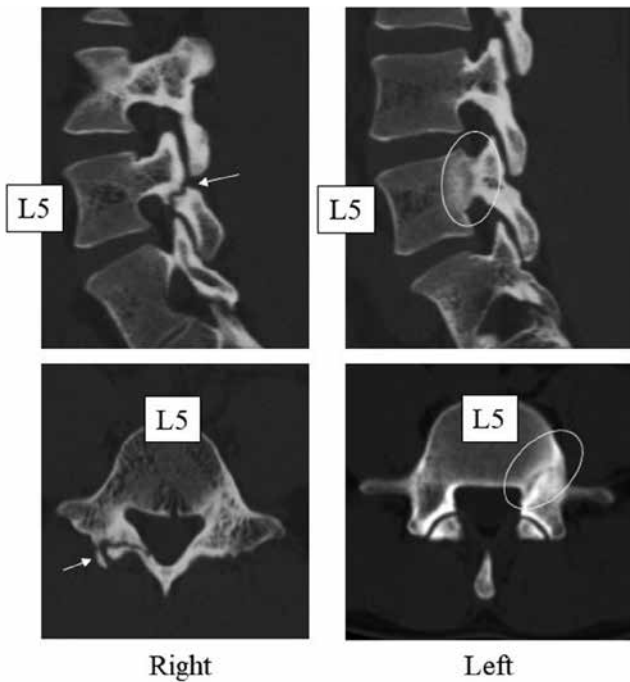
Computed tomography (CT) scans at the first visit show right-sided unilateral spondylolysis (terminal stage, arrow) and a high density area around a low density area at the left pedicle suggestive of a stress fracture (circle).
